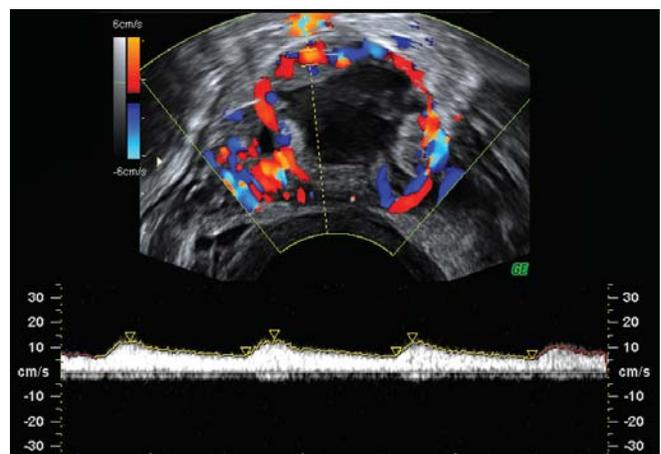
Corpus luteum color-PW Doppler shows rich diastolic flow and low RI
